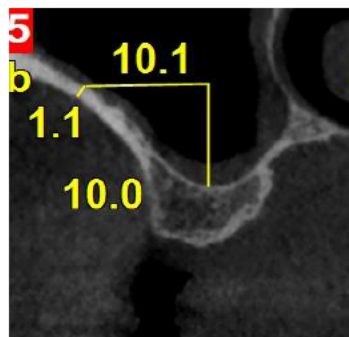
Measuring the lateral wall thickness at 10 mm superior to the sinus floor in CBCT cross-sectional image.
